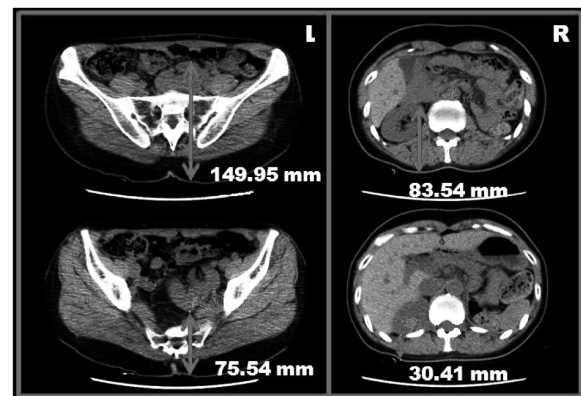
Selected CT images. All images were reviewed and selected manually. The analysis system was developed at Seoul Asan medical center.
